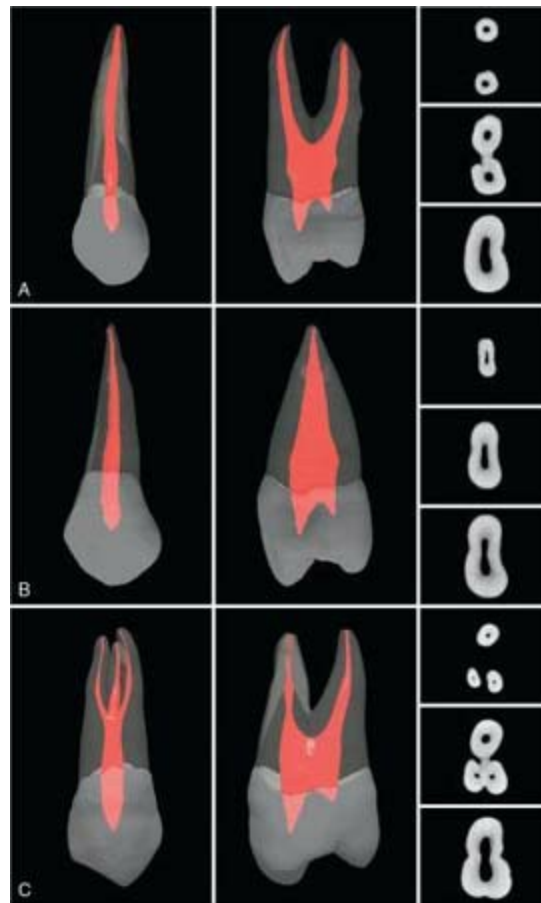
μ CT scans of maxillary first premolars. A, Common anatomic presentation of this tooth showing two roots. B, Premolar with only one canal. C, Premolar with three roots. All teeth are shown from both a buccal (vestibular) and a proximal perspective, along with the cross-sectional anatomy at the coronal, middle, and apical levels. (See Video 7.6 online at the Expert Consult site for rotational views of these teeth.)
